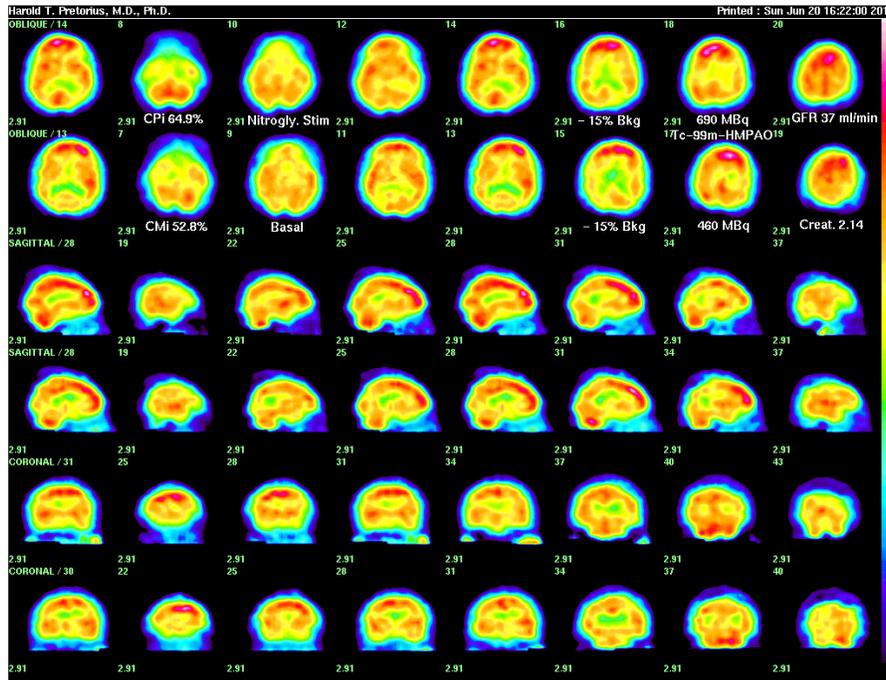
(above) Brain SPECT on the right with 0.8 mg nitroglycerin sublingual used for perfusion-stimulated images (top row of each of 3 paired rows of images; basal images are on the bottom row of each of the 3 paired rows) in a 75 year-old hypertensive African American man with relatively stable renal insufficiency. Serum creatinine over the last 2 years was 1.60 to 2.25 mg/dL, and near the time of imaging, 2.14 mg/dl, corresponding to GFR 35 to 45 ml/min. The patient has Mild Cognitive Impairment but normal cerebral flow reserve (FRi), here (64.9 minus 52.8)% >> 3%. Among 81 hypertensive patients average age (57.3+-14.5) years, without renal dysfunction, only 31.7% (26/82) had abnormally low FRi.
